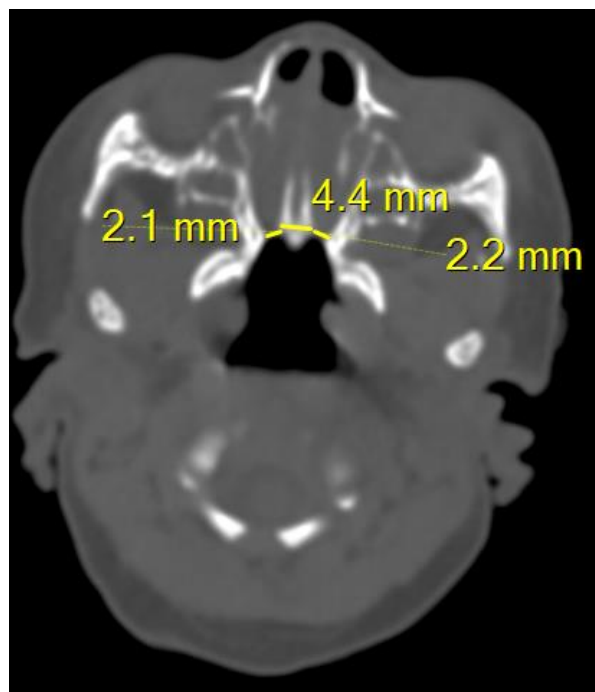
Axial CT bone window in a 1 day neonate who presented with difficulty of breast feeding and fast breathing since birth showing narrow posterior choanal aperture, thickening of the vomer, medial deviation of the bilateral medial maxillary sinus wall and the bilateral nasal cavity is filled by hypoattenuating content with air fluid level suggesting bilateral bony choanal atresia.
